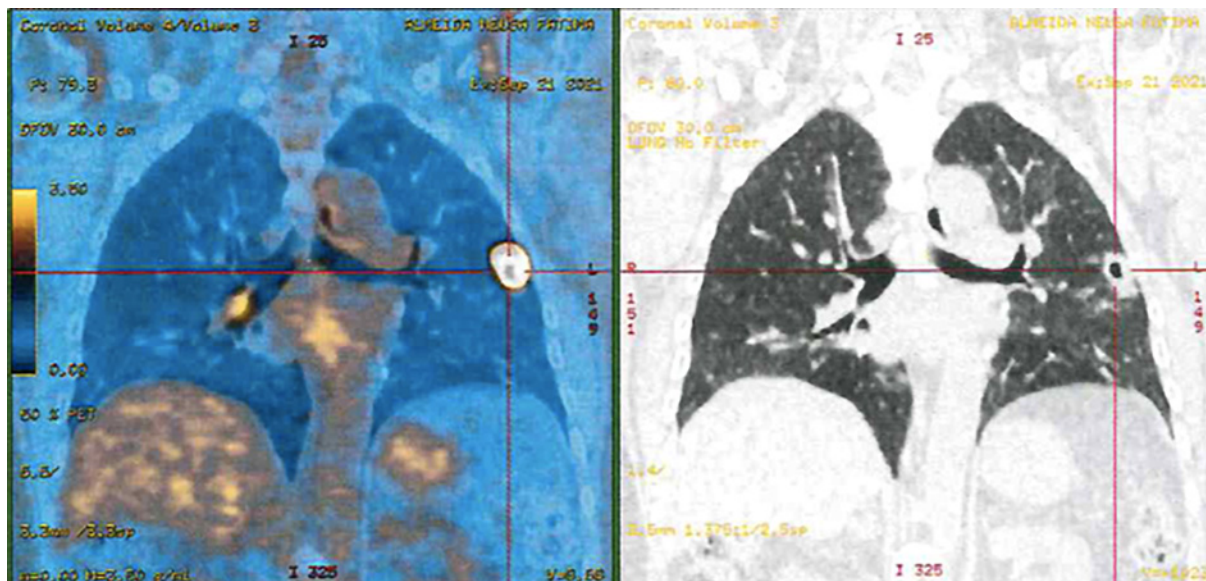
PET/CT showing a hypermetabolic nodular formation, subpleural, with central necrosis.
